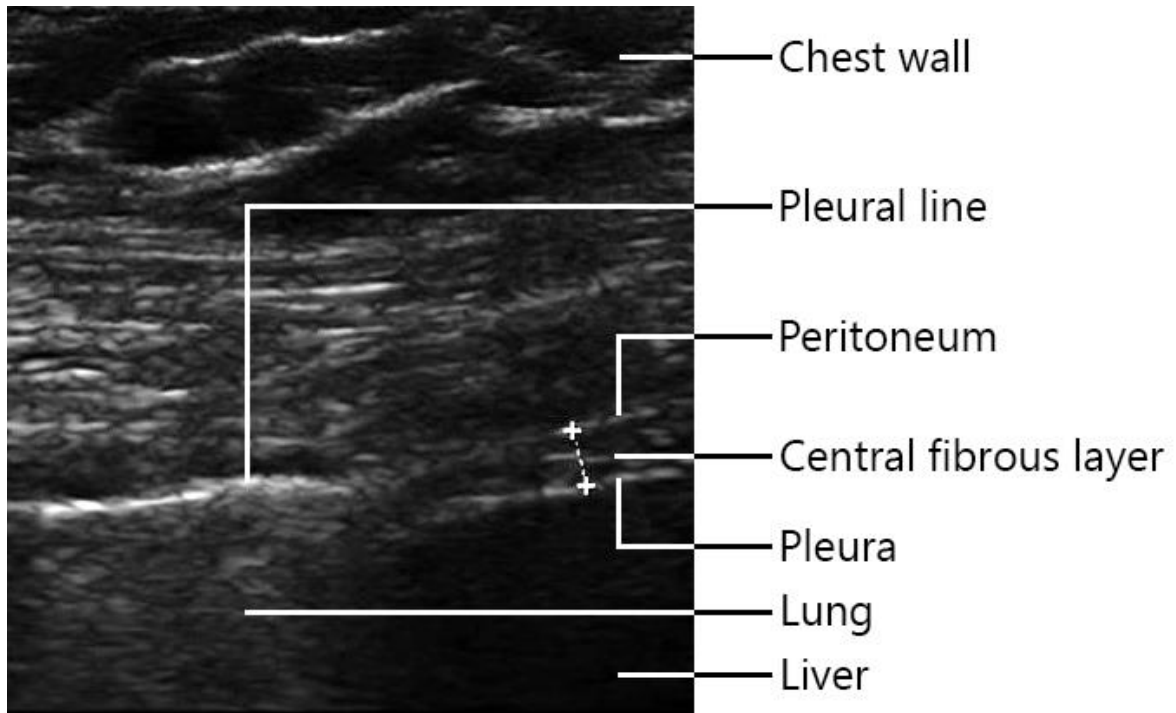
Ultrasound image of the diaphragm at the zone of apposition.
